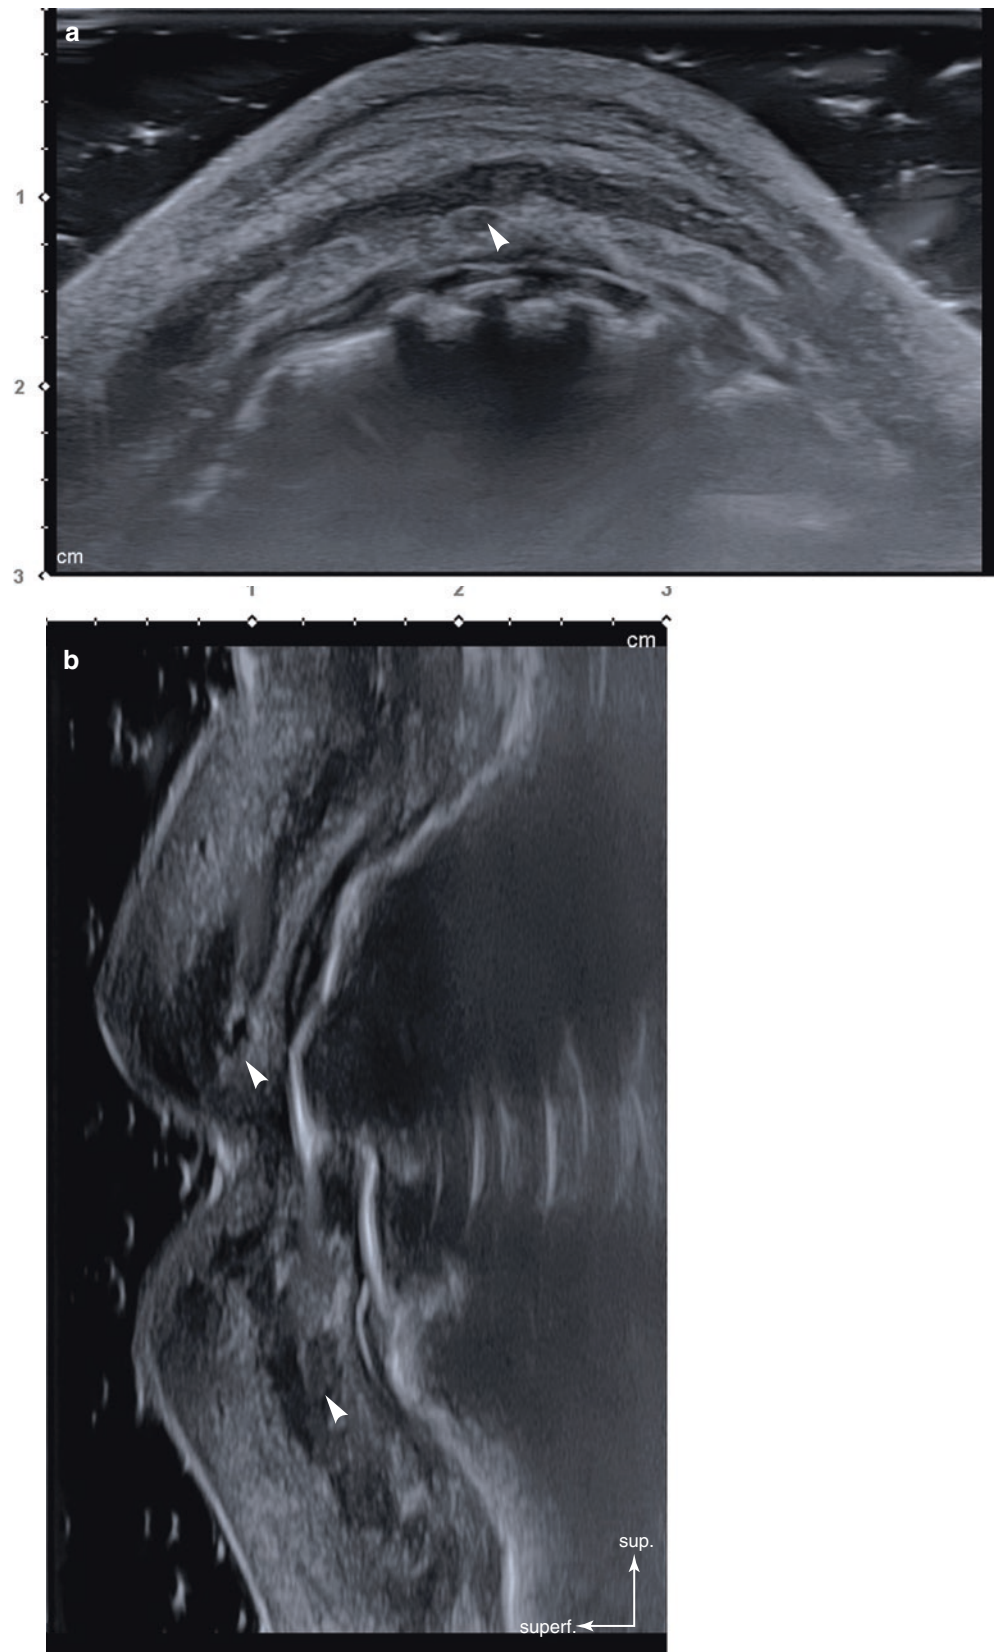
Ultrasonography representing the minor salivary glands (arrowheads) of the lip. (a) Transverse view, 15 MHz by linear transducer and (b) sagittal view, 15 MHz by linear transducer. (Published with kind permission of © Hee-Jin Kim 2020. All Rights Reserved)
